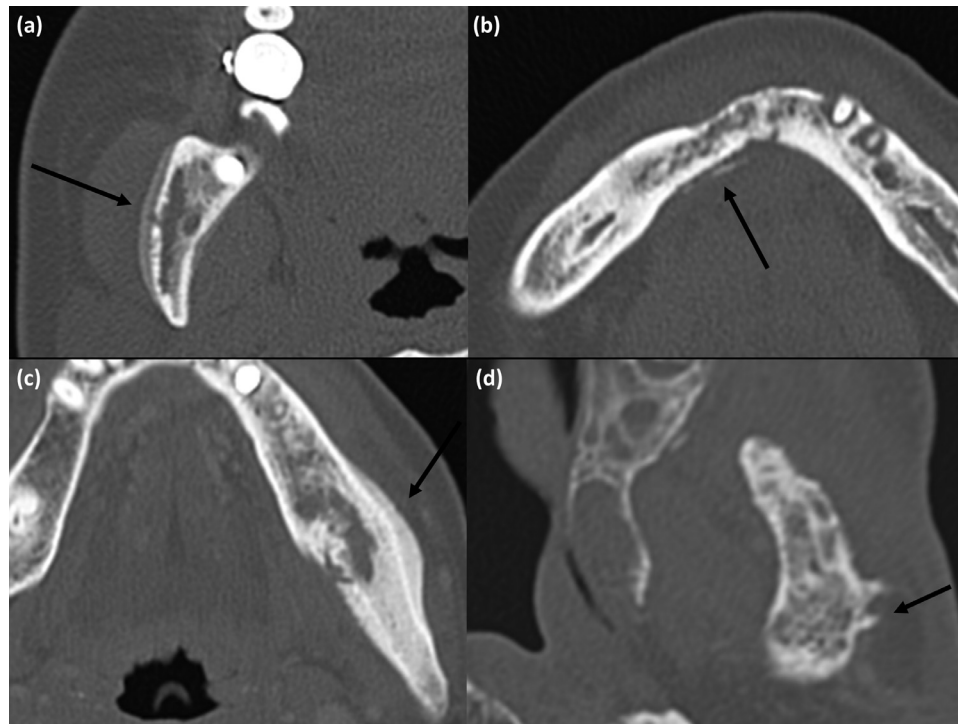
Images of periosteal new bone. Computed tomography (CT) images with bone window showed 4 types of periosteal new bone formation on the related cortical bone surface. (A) Continuous lamellar type. (B) Interrupted lamellar type. (C) Solid type. (D) Spiculated type .
